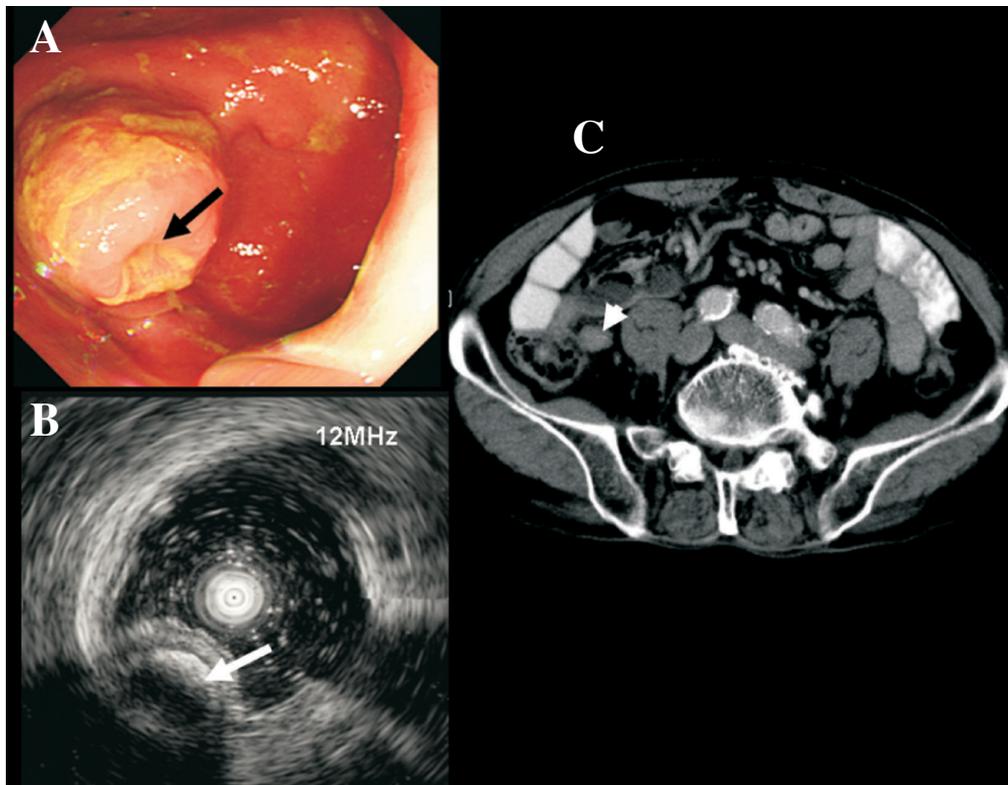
(A) A protruding SEL with central umbilication suspect the orifice of appendix in the cecum (black arrow) (NOTE TO AUTHOR: please rewrite). (B) EUS (12 MHz) was performed: a calcification lesion measuring about 10.7 mm with acoustic shadow was noted (white arrow) in appendix lumen (C) In CT scan, only a swollen appendix was noted. (white arrow head).
